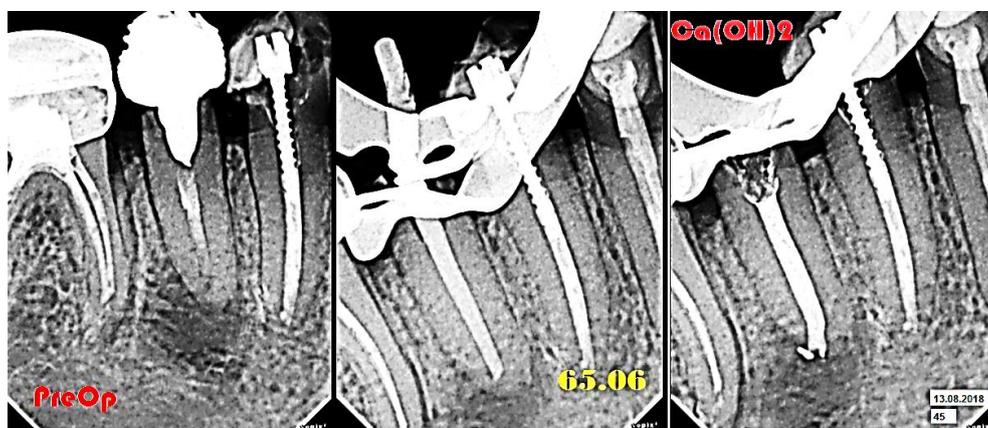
Example of determining the apical stop with a calibrated gutta-percha pin. Radiographs of tooth 45: initial situation (a); image with a calibrated gutta-percha pin of 06 taper (b); image with a temporary calcium-containing material in the root canal (c)
